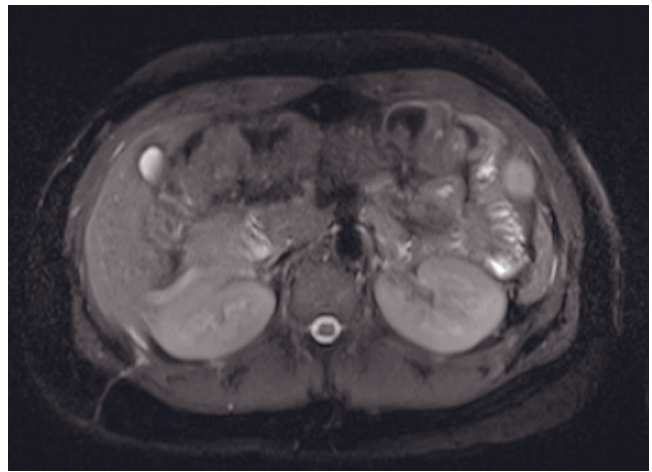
Fat suppression in echo-train spin-echo versus SGE sequences at 3T. Axial fat-suppressed T2-weighted echo-train turbo spin-echo sequence (a) with inhomogeneous fat suppression (*), probably due to multiple refocusing pulses and the MR physics nature of these pulses. Axial fat-suppressed T1-weighted SGE (b) shows homogeneous fat suppression (*) at the same anatomic level.
